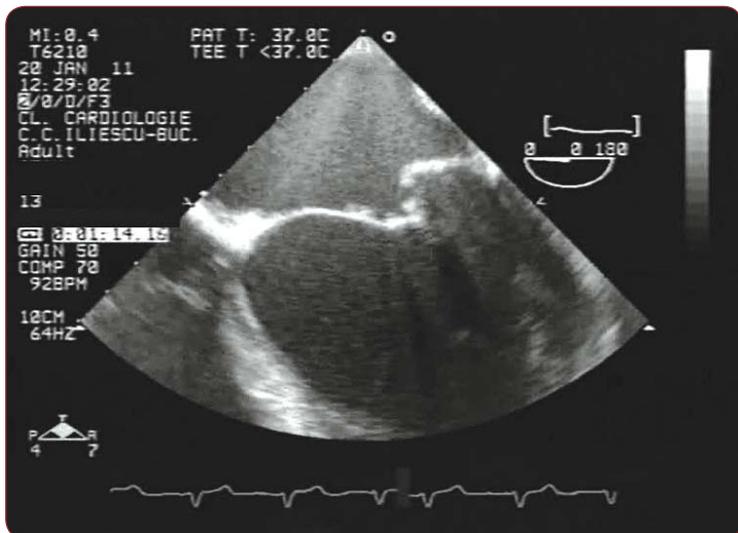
Transesophageal echocardiogram, section at 0 degrees, with the view of the vegetation on both mitral leaflets.
